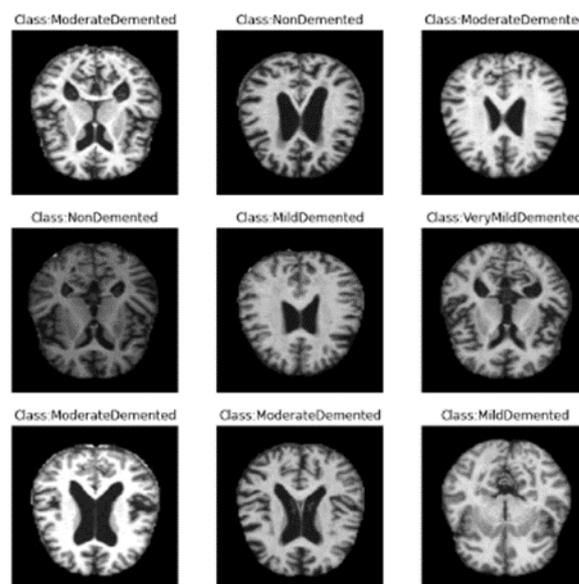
MRI Scans in Dataset
